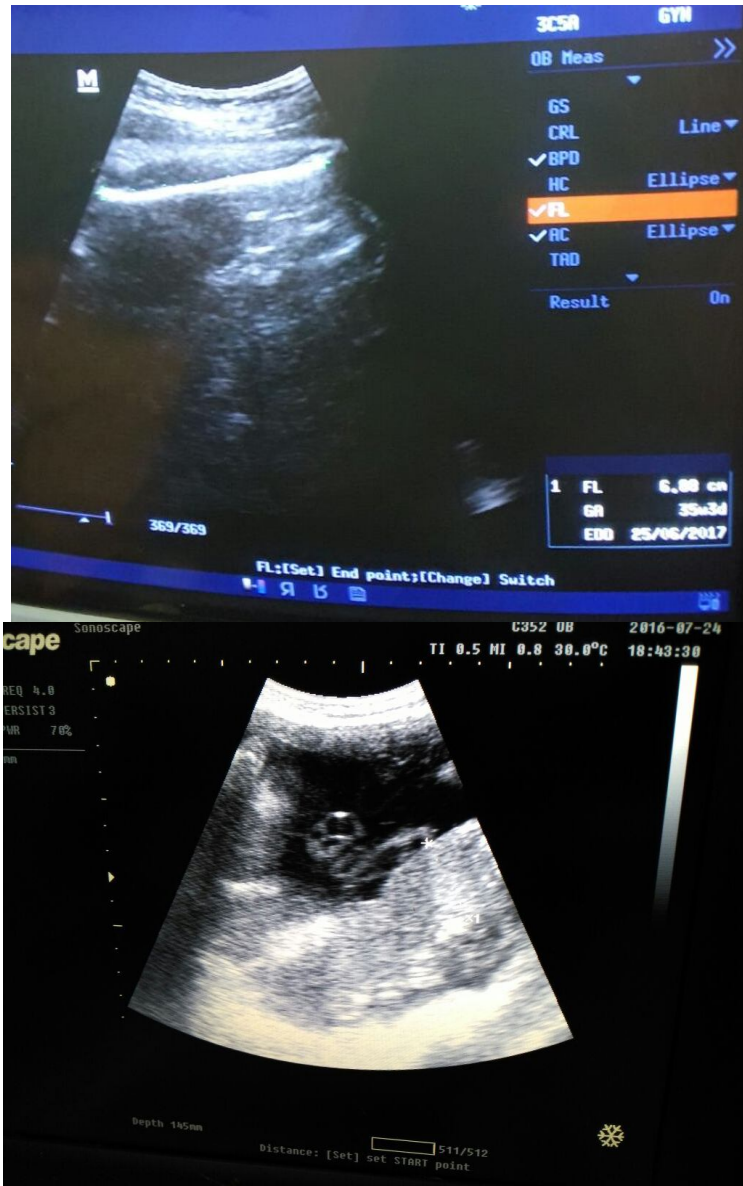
Transabdominal ultrasound image for 33 years pregnant woman shows placental thickness = 30 mm, gestational age = 35 weeks and 1 days.
